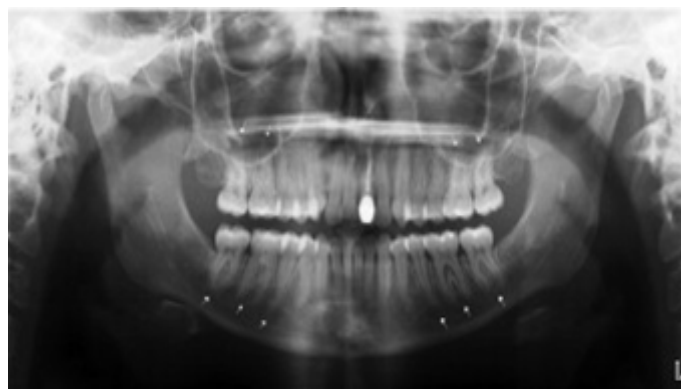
Panoramic radiograph of scleroderma patient with significant periodontal ligament space widening, particularly in the mandibular and maxillary posterior teeth.
